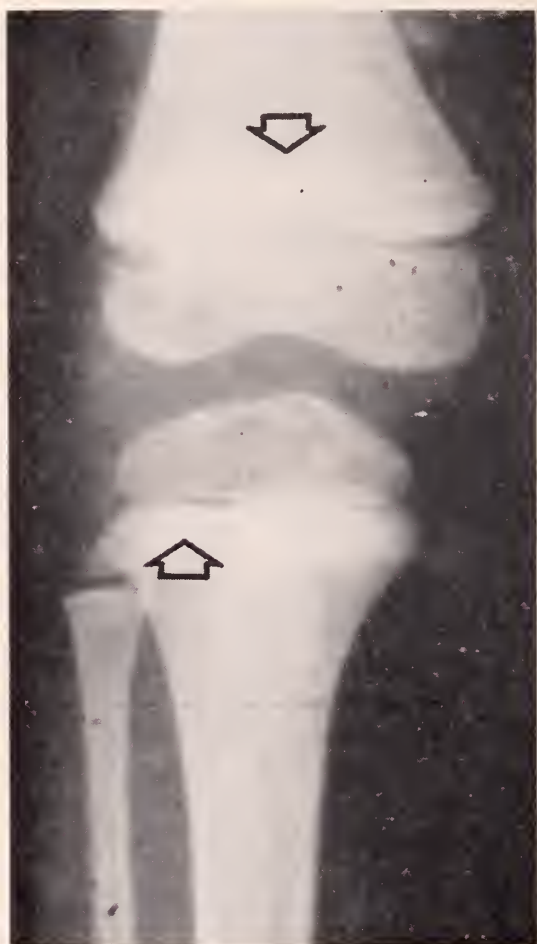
Child with pica. Roentgenogram of knee joint. Chronic lead poisoning resulting from ingestion of plaster. Note lead lines indicated by arrows.
